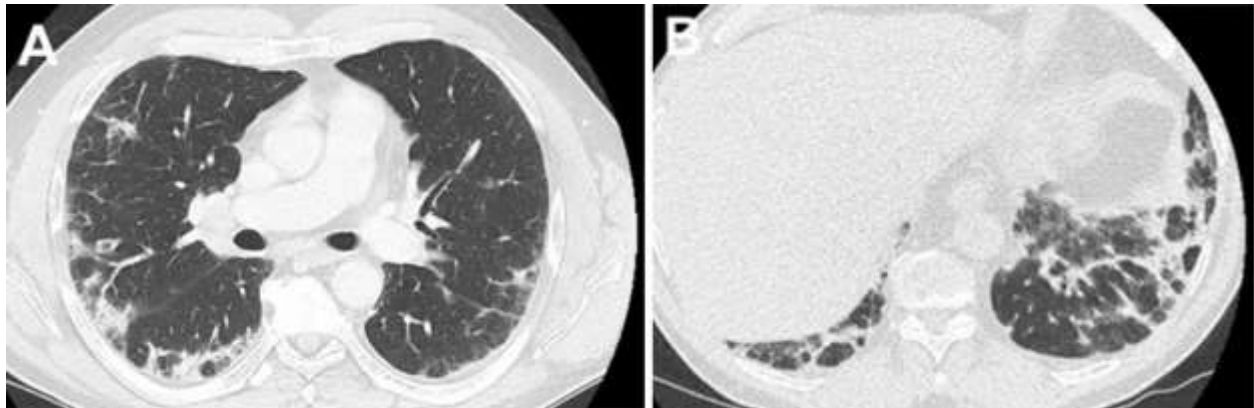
Representative images from the thoracic CT in lung windows from outside emergency room visit.
